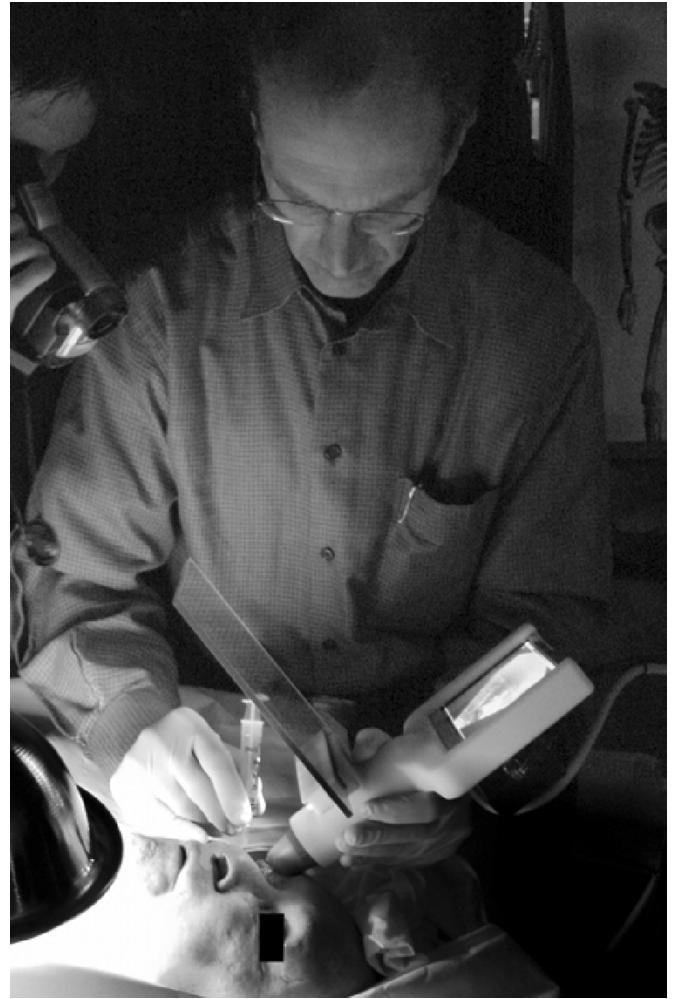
Ultrasound augmentation by tomographic reflection: Sonic Flashlight [82], [83] ©2000 IEEE.
